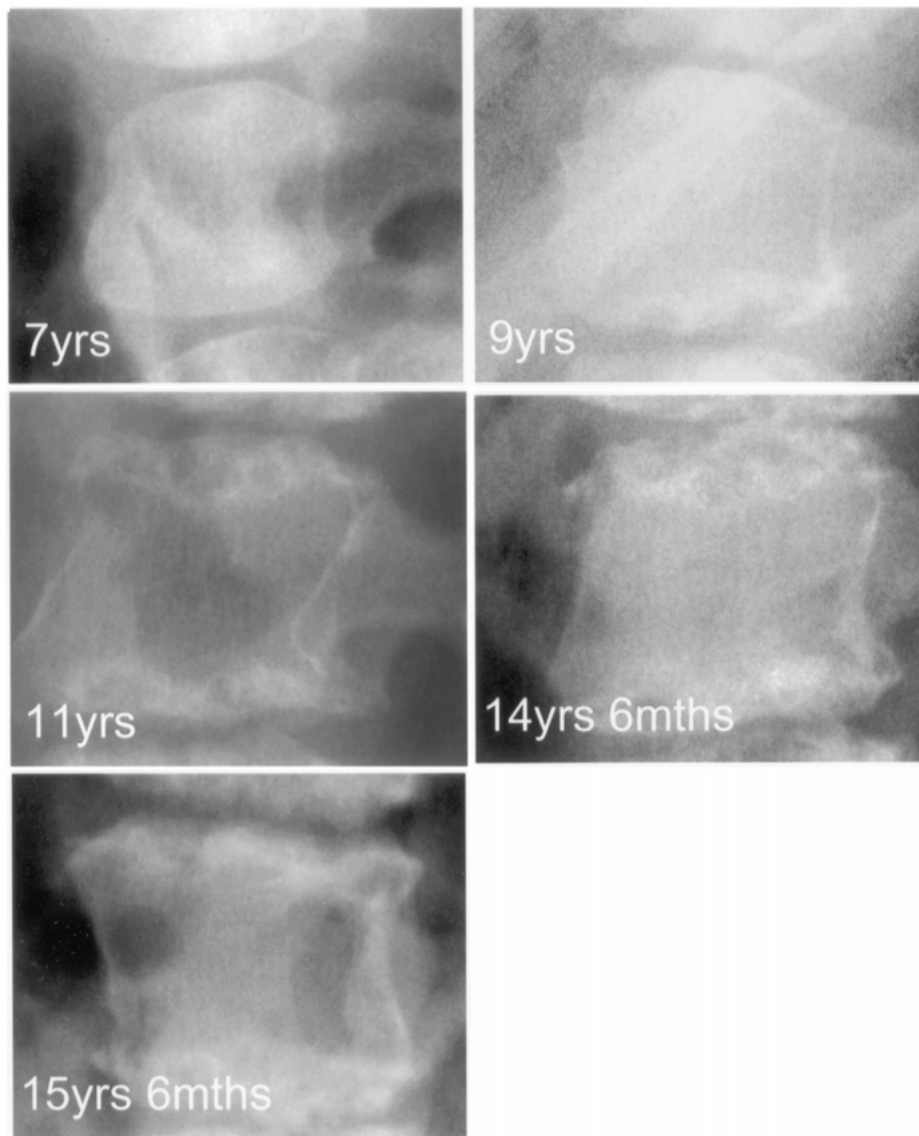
Lateral radiographs of the first lumbar vertebra of subject B, at ages 7, 9, 11, 14½, and 15½ years, showing the appearance of dysostosis multiplex in the early films, with anterior hypoplasia of the vertebral body, but also progressive erosion of the superior and inferior endplates. The final picture, obtained after one year's pamidronate therapy, shows increased radiographic density at the end plates, but persistence of the erosive changes. The appearances were similar in subject A
